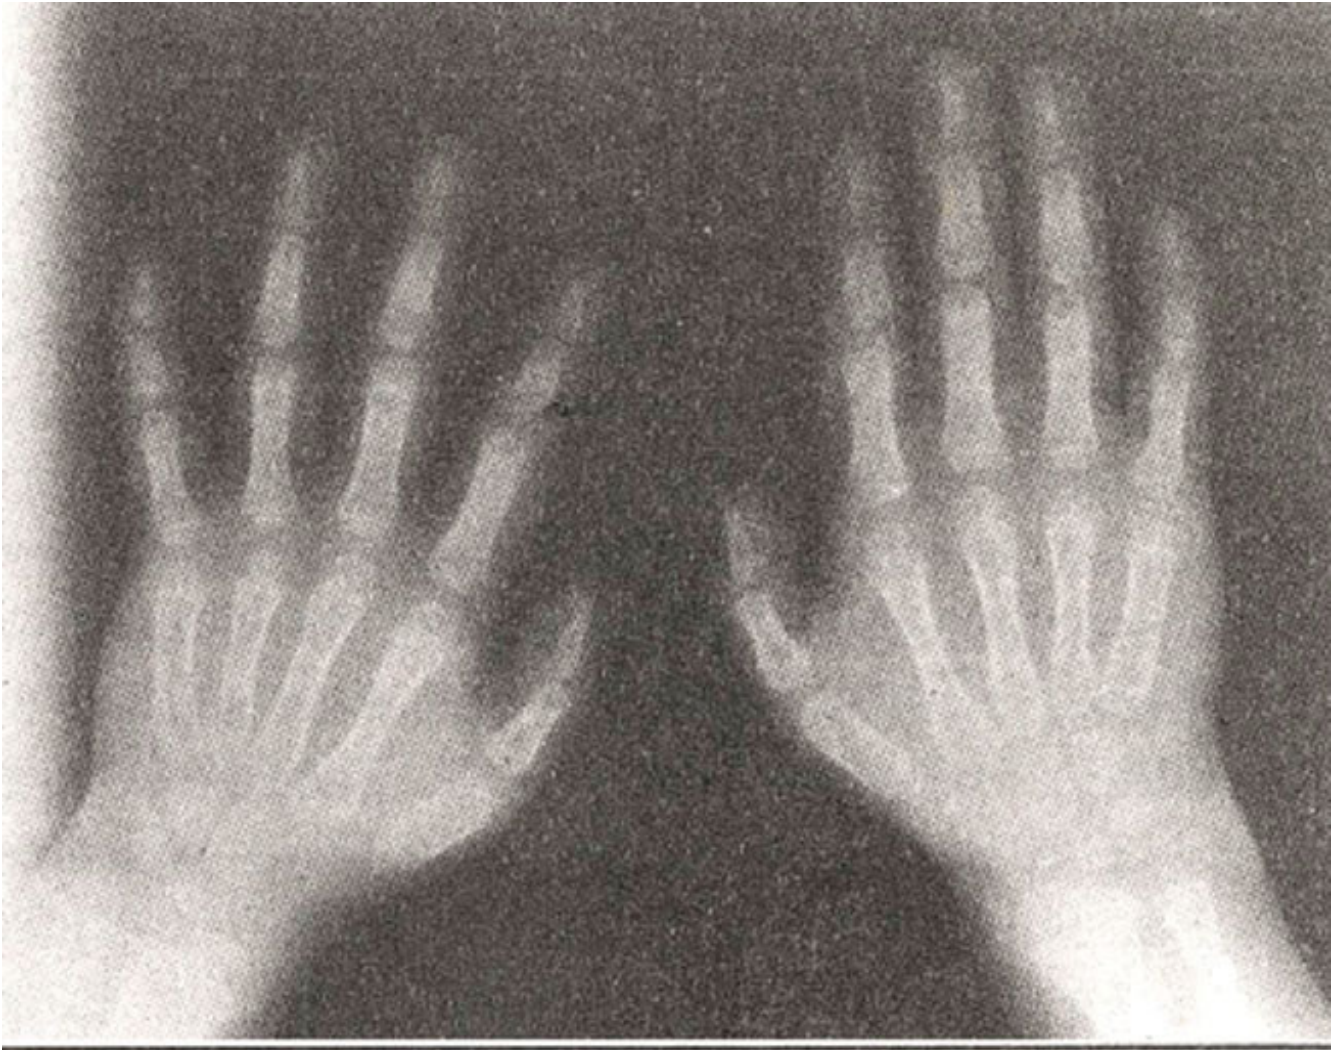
Radiograph of the hands showing bilateral hypoplasia of the first metacarpals.
